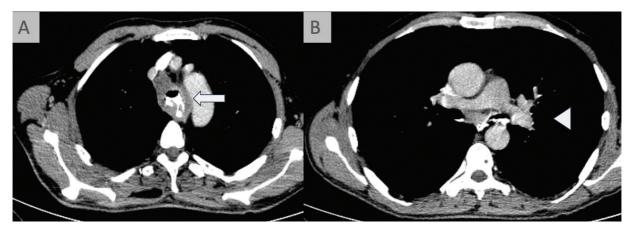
Esophagobronchial fistula in esophageal cancer. (A and B) Axial and coronal contrast-enhanced computed tomography (CT) scan show extravasation of contrast into the trachea (arrows) and left main bronchus (arrowhead) suggestive of tracheoesophageal and esophagobronchial fistula.
